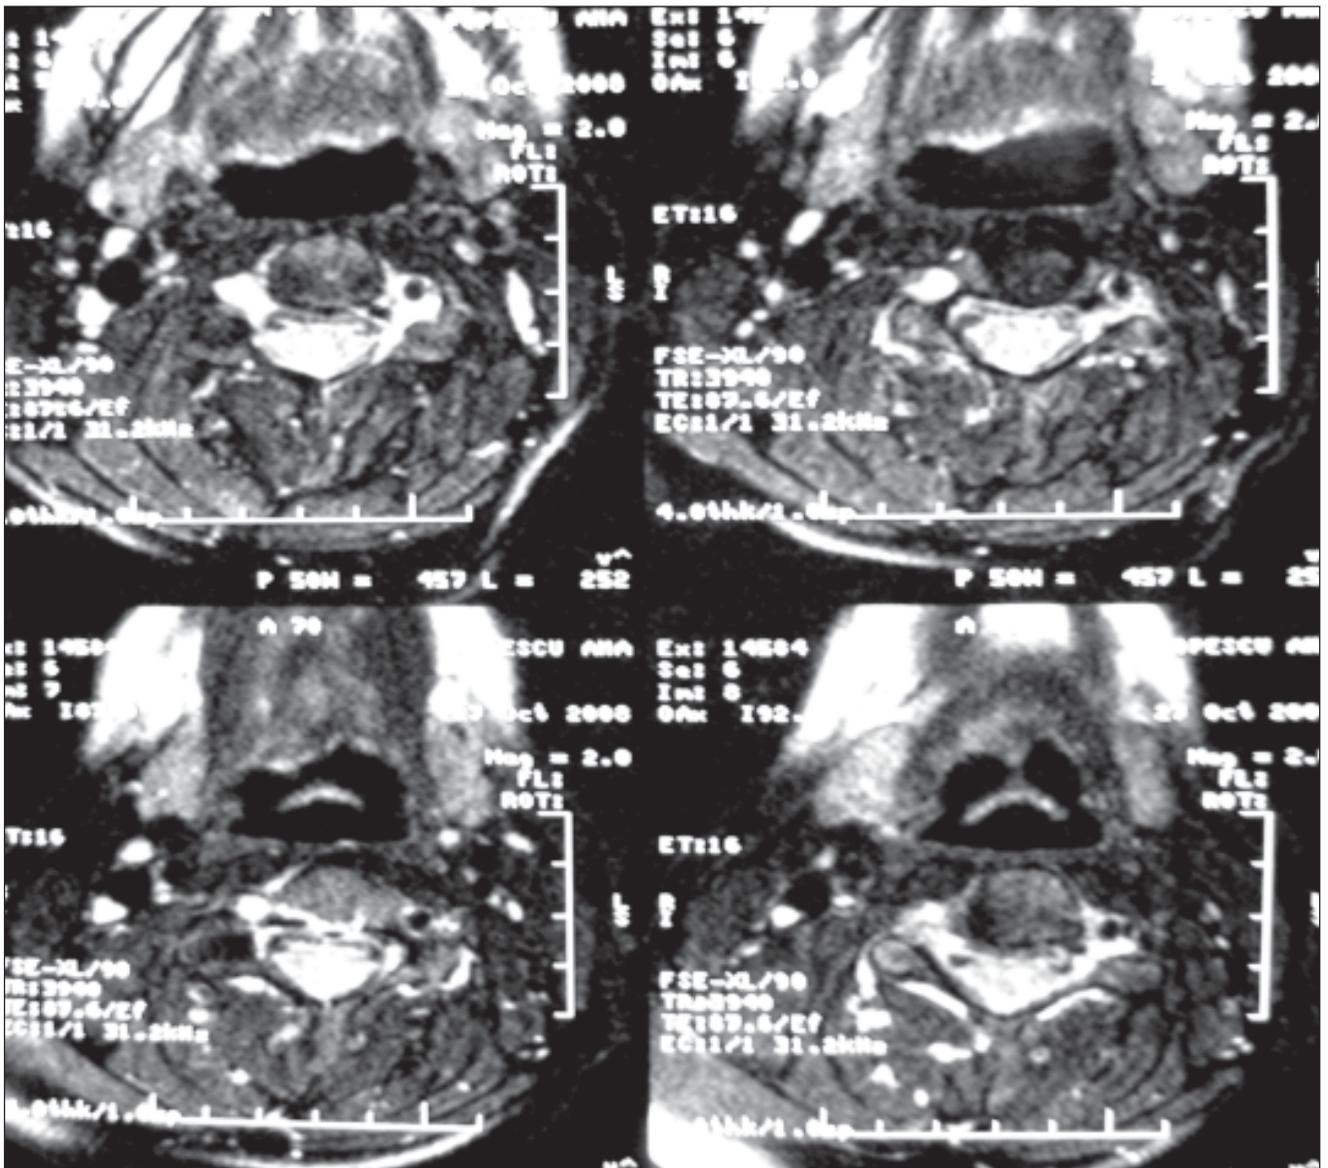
Cerebral MRI - T1 weighted image - the double lumen on the right vertebral artery level with no flow on this level.
